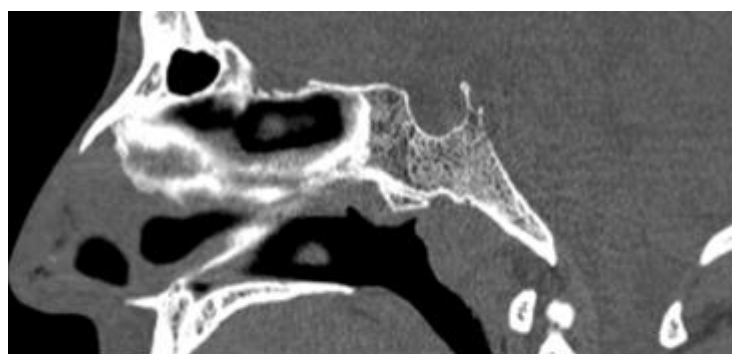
Sagittal CT revealing sphenoid sinus agenesis (extremely rare).
